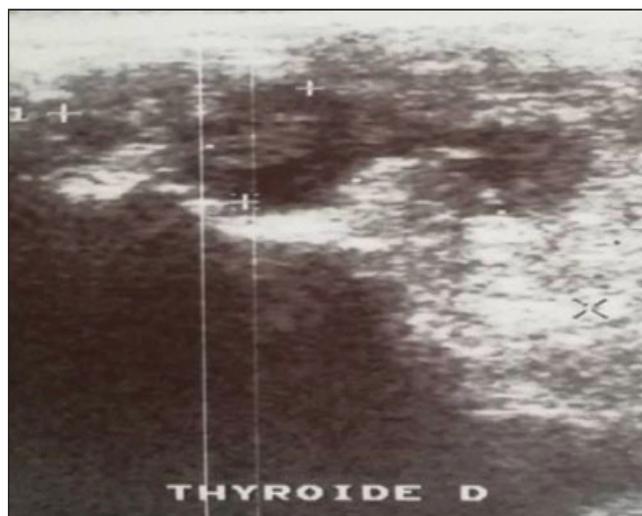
Thyroid Ultrasonography (US): a 18-mm hypoechoic well circumscribed solid mass with relatively benign US features
